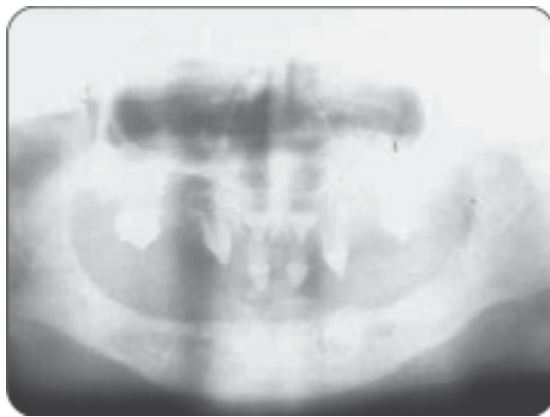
Hereditary ectodermal dysplasia X-ray showing almost complete lack of tooth formation in lower jaw
